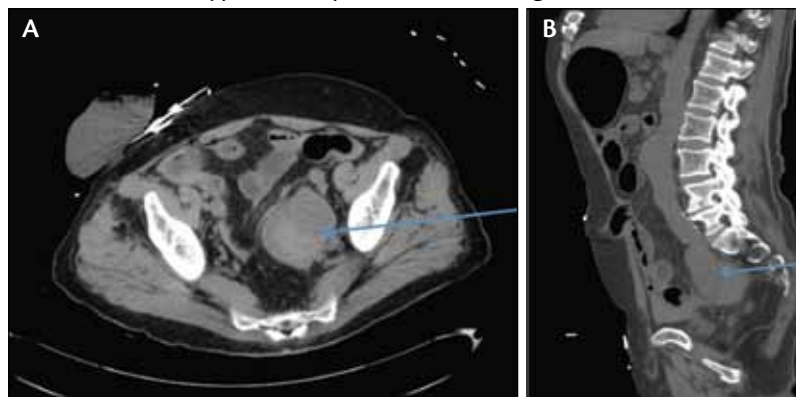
Contrast CT imaging before repair (A) and sagittal view (B).
